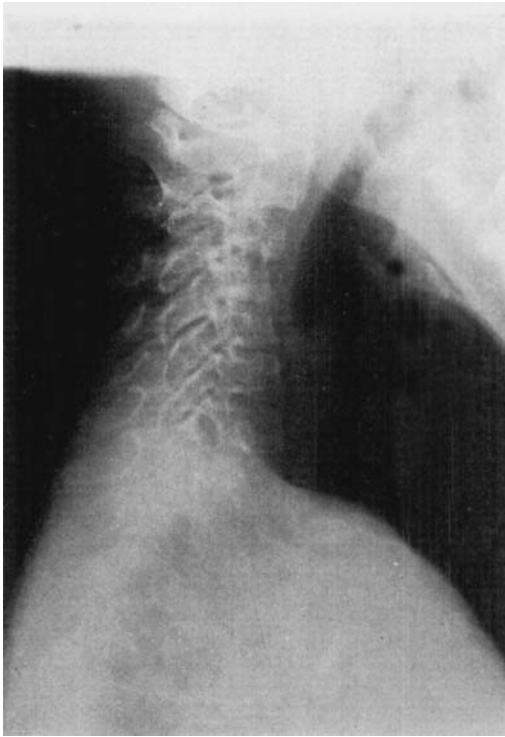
Lateral X-ray of cervical spine 12 weeks after surgery and 6 weeks after removal of the Minerva plaster cast.
